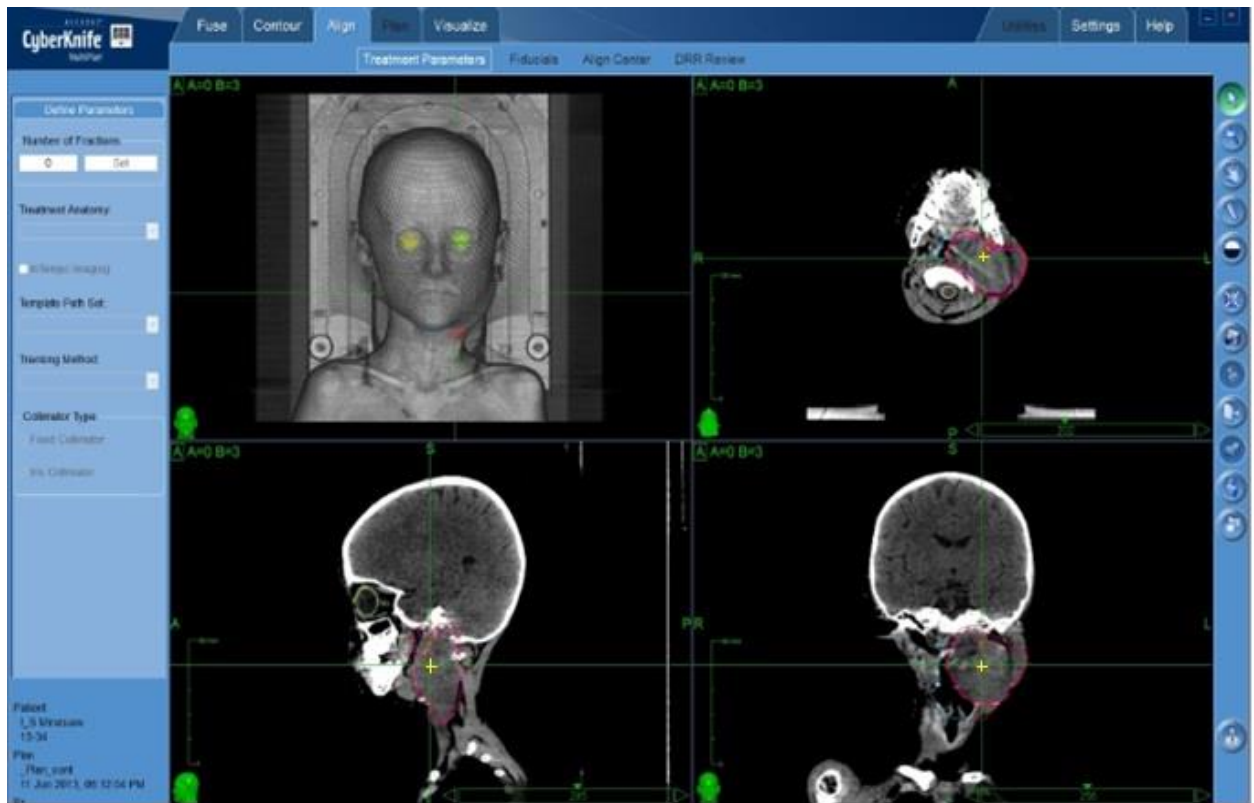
CT - images at the stage of topometric preparation of the patient
